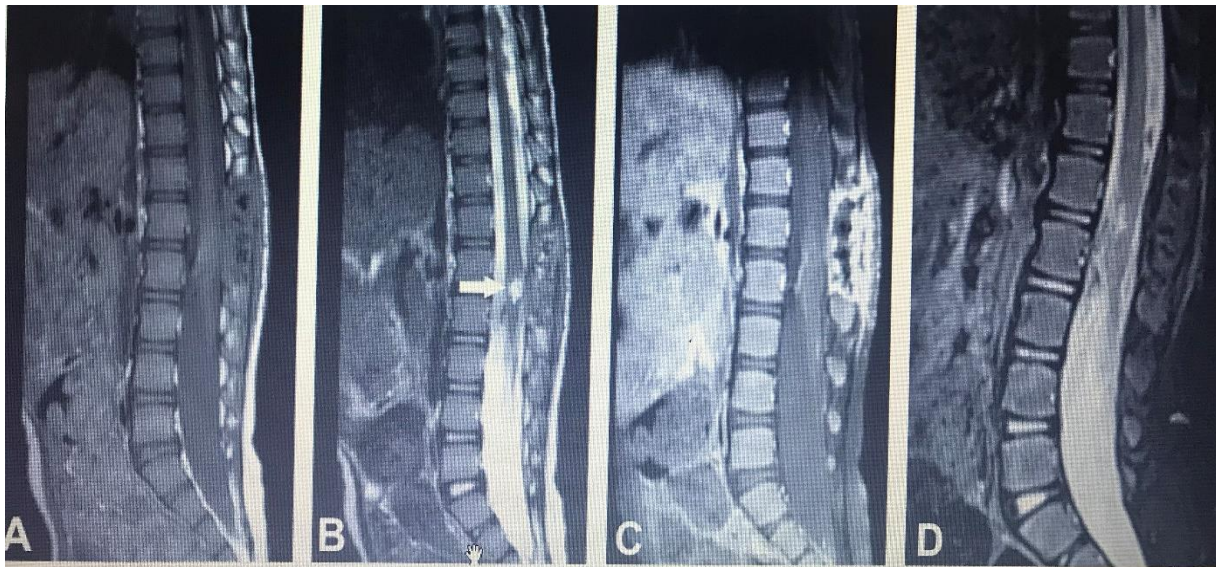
Postoperative MRI. The disappearance of syringohydromyelia is noted. There is no residual tumor. The medullary cone and fibers of the cauda equina are decompressed. A - T1-weighted; B, T2-weighted (arrow indicates hyperintense image, which is regarded as myelomalacia due to chronic compression that persisted after cyst resection); C - contrast sagittal section 2 weeks after surgery; D - T2-weighted sagittal section also shows a significant reduction in myelomalacia 2 months after surgery.
